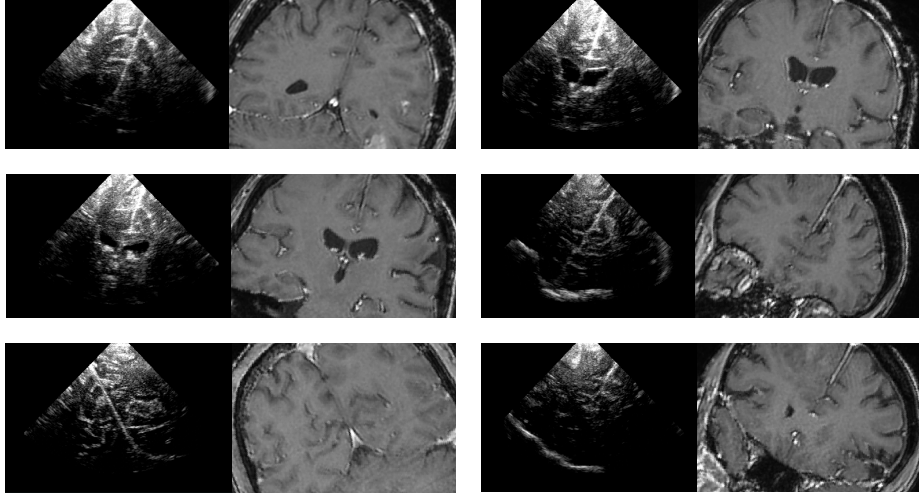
Six examples of the intra-operative B-mode US and the corresponding pre-operative MR images from the BITE database. Note that the sulci and ventricles appear respectively hyperechoic and hypoechoic in the US images.
